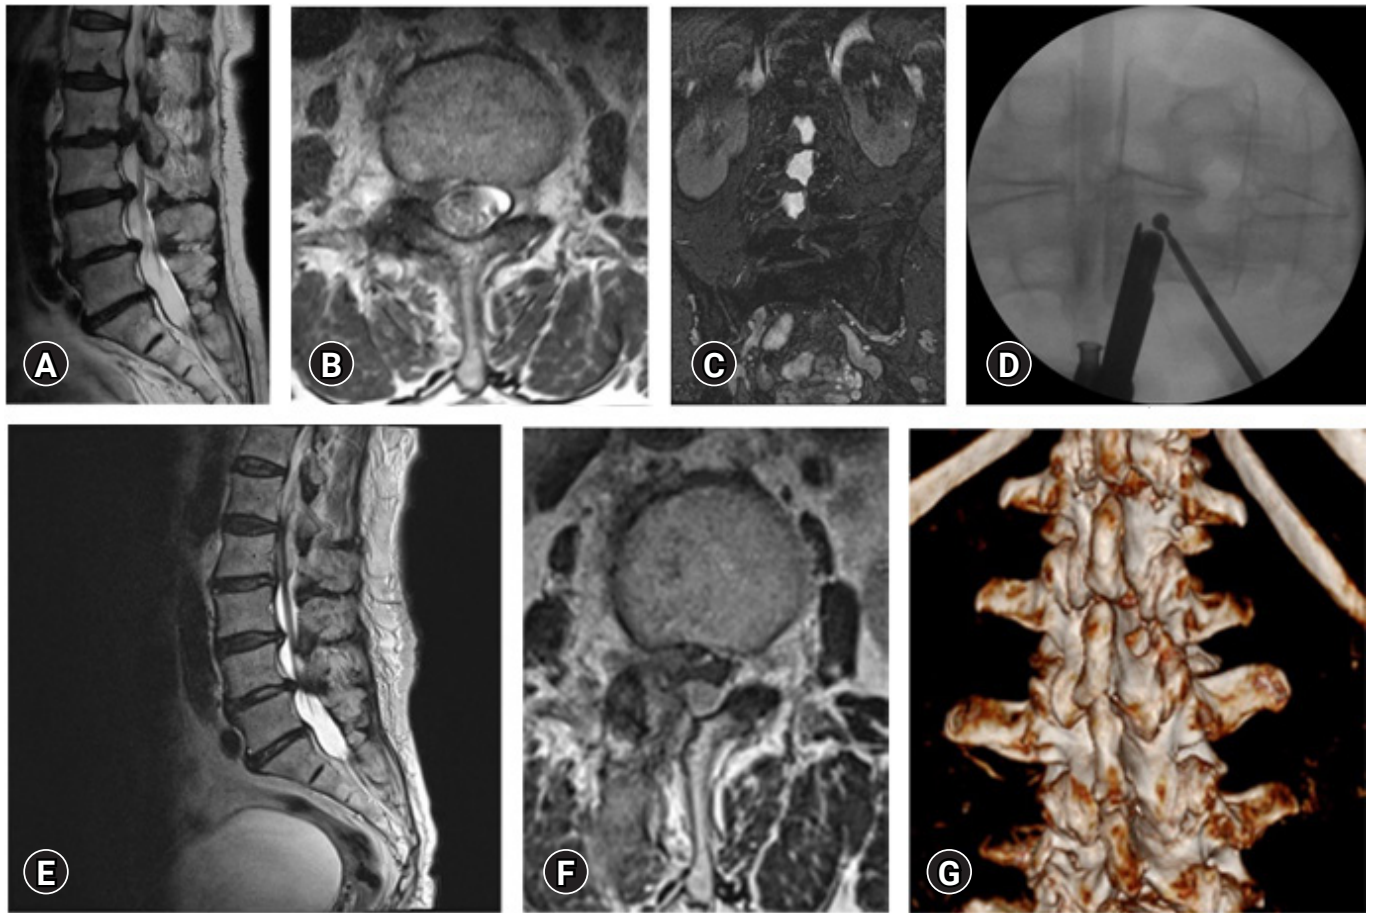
Preoperative sagittal MRI showing right paracentral extrusion with high-grade up-migrated disc from L2-3. (A) Sagittal MRI, (B) axial MRI, (C) myelogram. Images during and after translaminar keyhole discectomy by UBE. (D) C-arm intraoperative image of the scope and diamond burr drilling the keyhole. (E) Postoperative sagittal MRI, (F) postoperative axial MRI, (G) postoperative 3D-CT.
